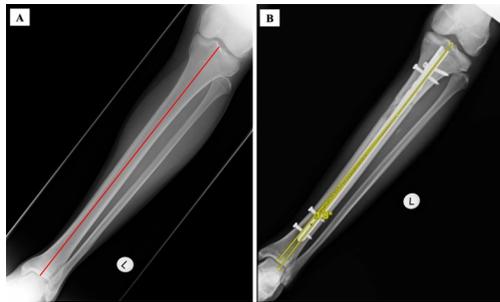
Anatomical axis of the tibia on anteroposterior view plain radiographs. The axis is drawn from the midpoint of the tibial spines to the distal end of the tibia, as depicted by (A) the red line on a normal tibia and (B) the yellow line on a tibia with a post-intramedullary nail (IMN), indicating a minimal valgus malalignment of 1.8 degrees.
